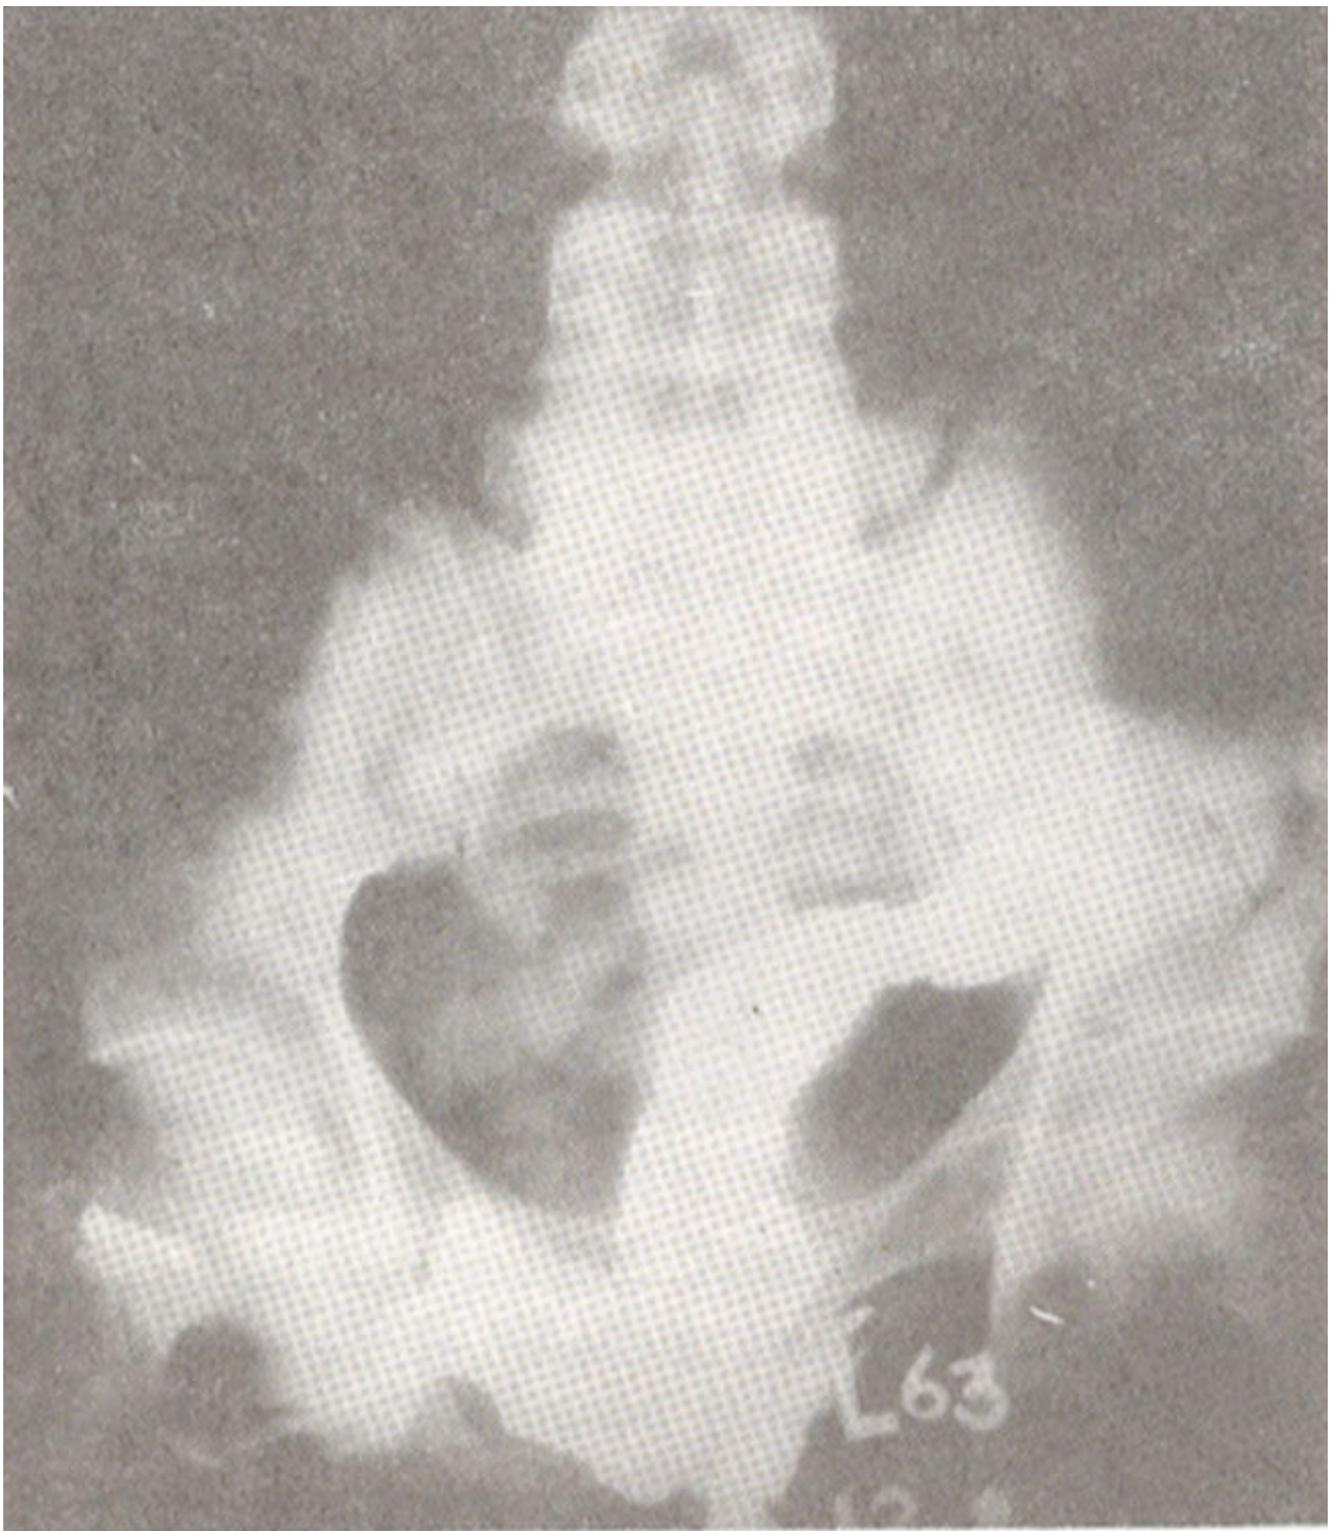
Per Colostomy Barium X-Ray. Post Operative.
